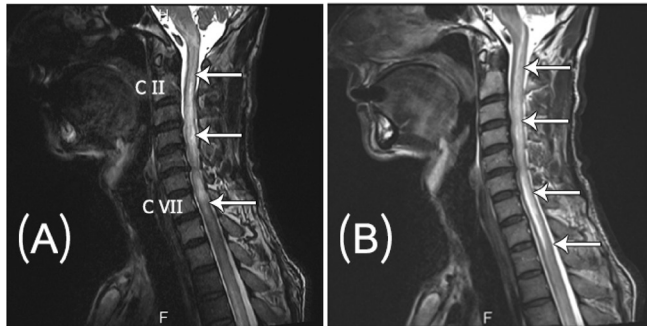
MRI dorsal spine sagittal T2-weighted images. Imaging made at the first presentation (A) and ninety-five days after (B). On image A the cervicomedullary lesion appears hyperintense at the level of cervical vertebrae II to VII. On image B the lesion expands to cervical vertebra IX, showing dissemination in time and space.
